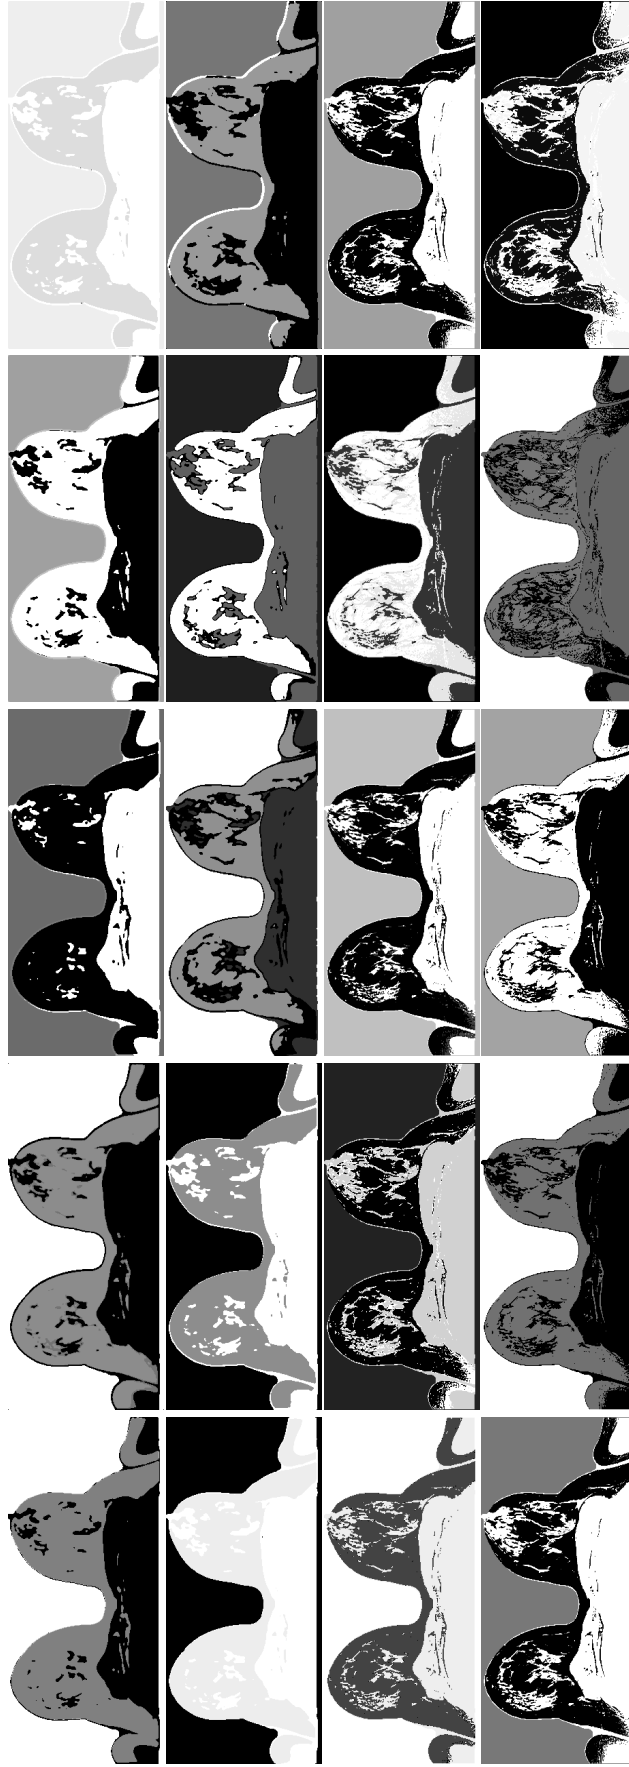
The output of the same MRI volume in the middle slice (transverse view) from NN of ten iterations for each sub-network using the first approach. The first two rows are from the first sub-network of the size filter  $[1 \times 3 \times 3]$ . The second two rows are from the second sub-network of the size filter  $[1 \times 1 \times 1]$ .
